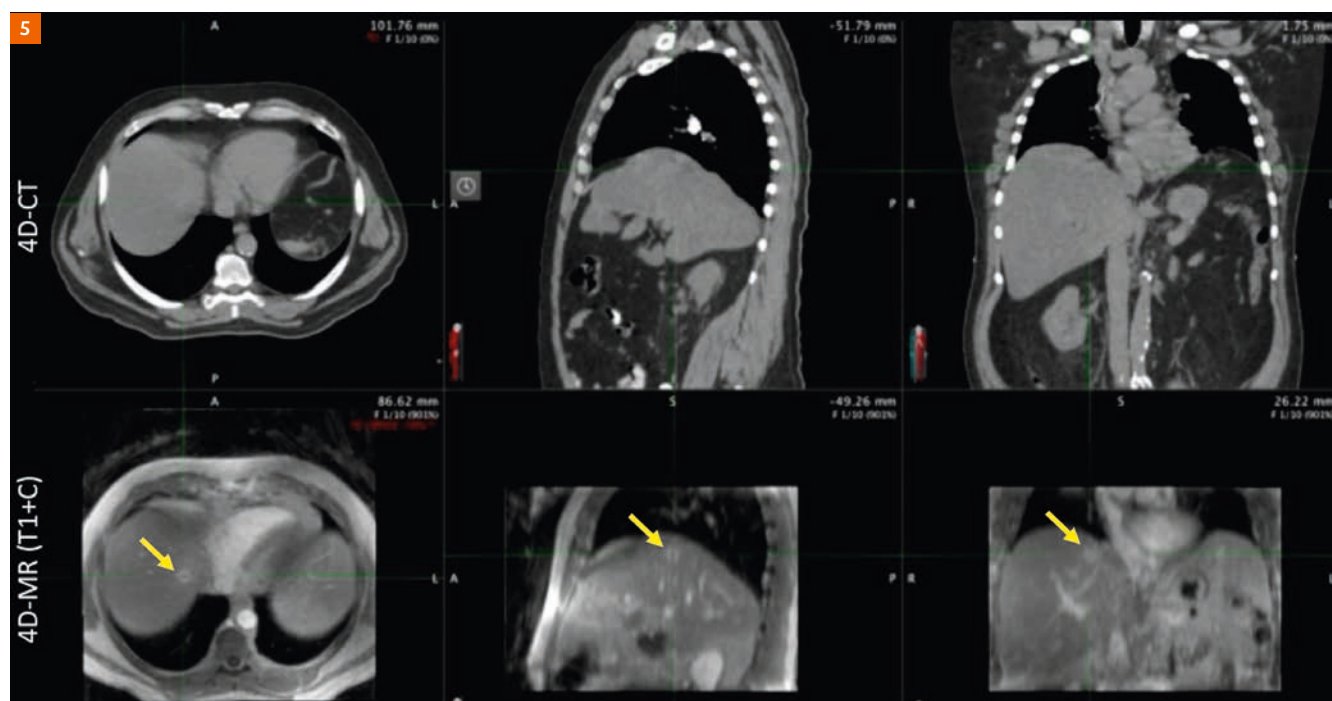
End expiratory 4D-CT (top) and post-Multihance T1-weighted 4D-MR (bottom) images of a liver metastasis patient. The enhancing liver met is more readily visible on the 4D-MR images (yellow arrow).
